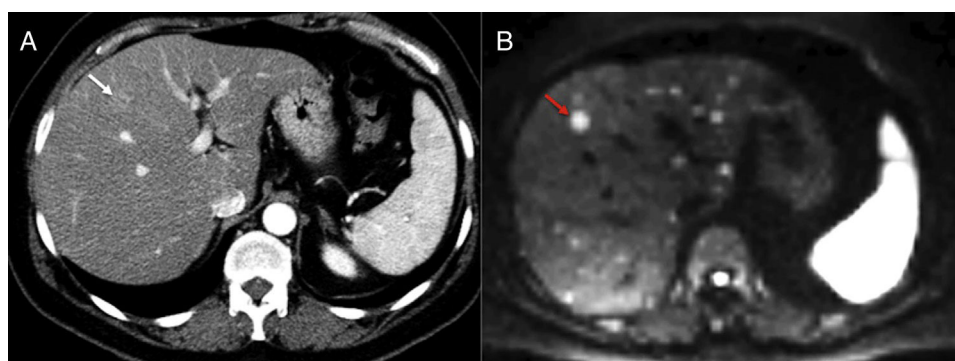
Staging of pancreatic tumors using DWI. Patient operated on one pancreatic neuroendocrine tumor with high levels of chromogranin A during follow-up. The image from the CT scan with contrast in the arterial phase and on the axial plane (A) shows one slightly hypervascular hepatic lesion (white arrow). At the same level of the CT scan, the DWI of the liver with a $b800$ value (B) confirms the existence of this lesion (red arrow) and shows countless hepatic subcentrimetrical lesions with hypersignal in diffusion corresponding to hepatic metastases.
